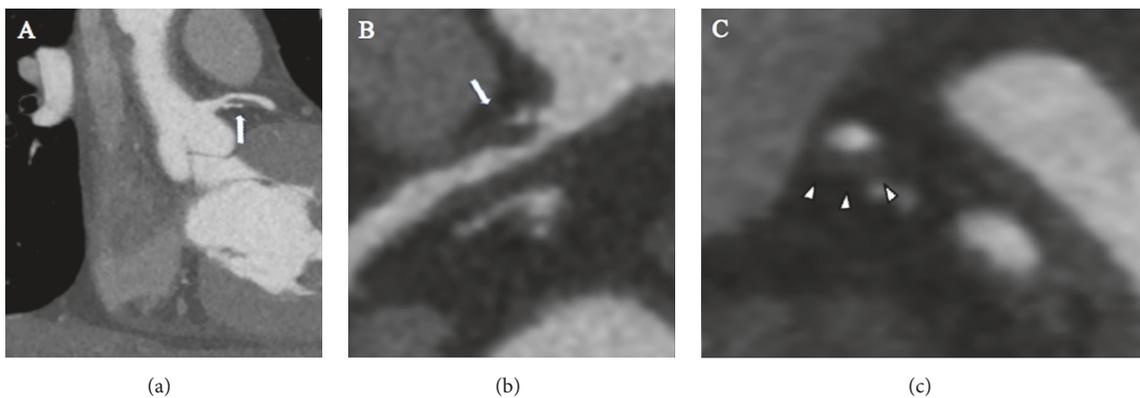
A fifty-three-year old-male patient with history of arterial hypertension and dyslipidemia was admitted at the emergency department for atypical chest pain. Cardiac computed tomography acquired during hospitalization showed in multiplanar reconstruction a soft plaque determining stenosis of 70% in proximal left anterior descending artery ((a) (b) arrow). Cross sectional images showed positive remodeling of a soft plaque ((c) arrowhead).
